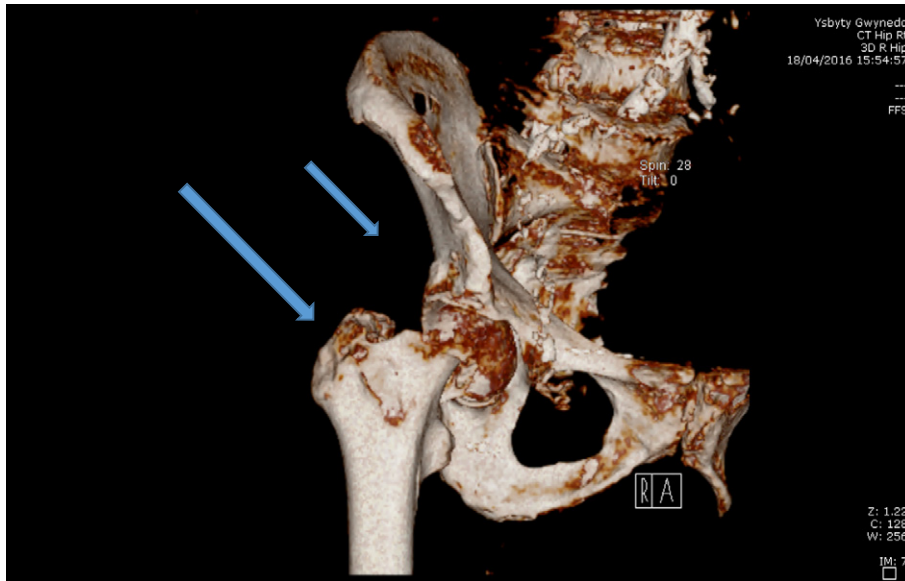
3-D CT scan images showing intracapsular and extracapsular fracture neck of femur.
